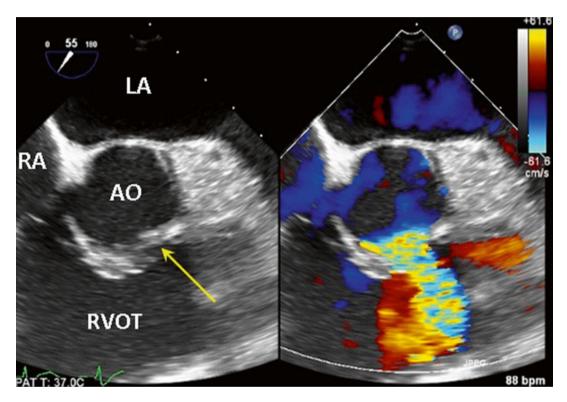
Two-dimensional transesophageal echocardiography (2D TEE) color compare, short-axis view, showed a supracristal VSD (*arrow*) located at the 5 o'clock position and adjacent to the PV with flow from LV outflow tract to RV outflow tract
